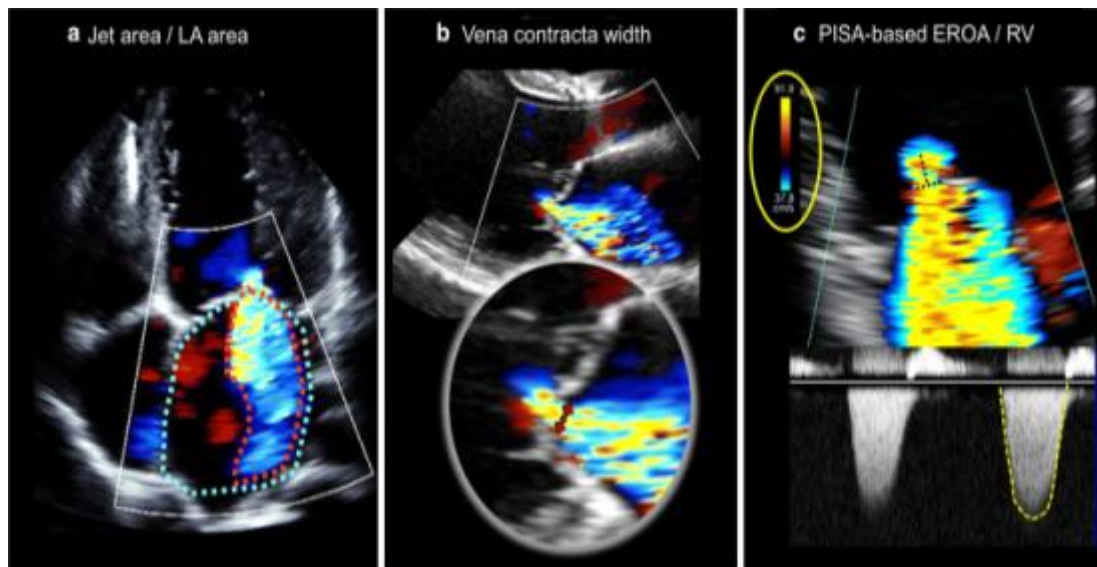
Grading methods of MR. a Ratio of color Doppler jet area to left atrium area. b Vena contracta width. c Proximal isovelocity surface area method (5).
